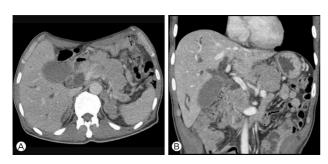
Abdominal computed tomography (A) diffuse mass in the pancreas and peripancreatic area, with infiltration to the whole pancreas (B) the bile duct was compressed by the mass, the intrahepatic bile duct was dilated.
